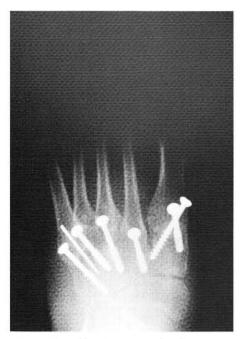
Lisfranc's joint arthrodesis postoperative dorsoplantar radiograph
